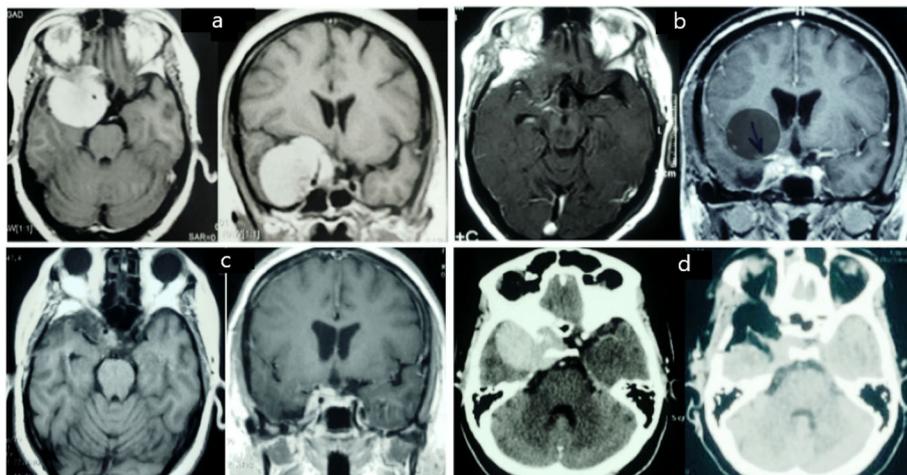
a–d Preoperative and postoperative imaging of case 1 with right ACM (type I). a MRI brain with enhancement axial and coronal view showing right ICA encasement and CS invasion by the tumor. b Postoperative MRI with enhancement showed the extent of tumor resection. c Last follow-up MRI with enhancement after SRS-GK, tumor control with no regrowth was achieved. d Immediate postoperative CT scan showing the right anterior clinoid was removed
